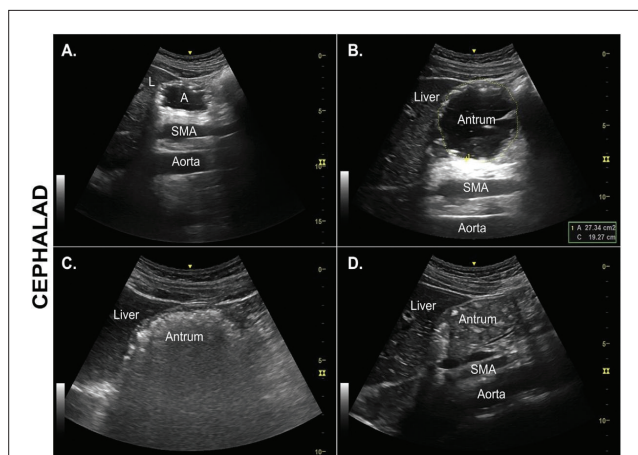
Ultrasound representation of gastric antrum.
